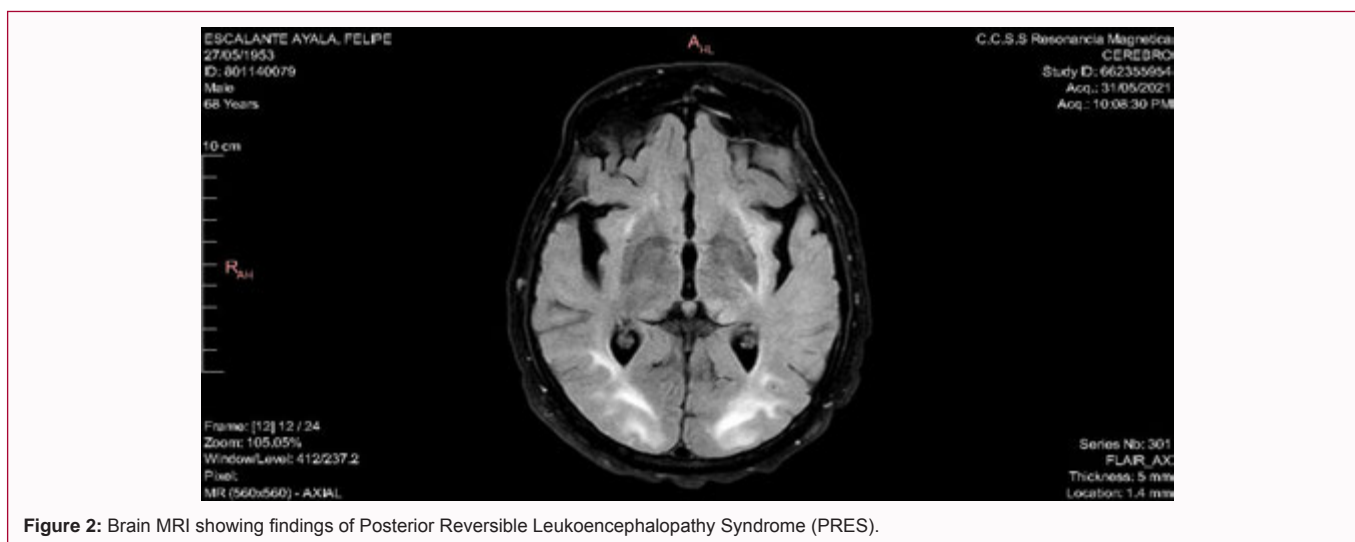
Brain MRI showing findings of Posterior Reversible Leukoencephalopathy Syndrome (PRES).
